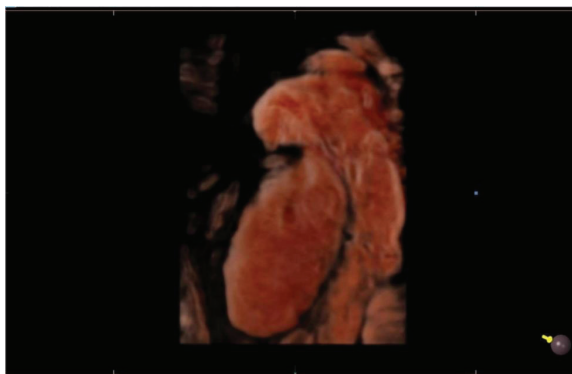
Volume-rendered three-dimensional ultrasound image showing an apparently small ovoid testis and a disproportionately prominent, elongated epididymis along its posterior aspect. The appearance is descriptive and should be correlated with quantitative measurements, conventional grayscale imaging, color Doppler findings, semen analysis, and hormonal assessment.
